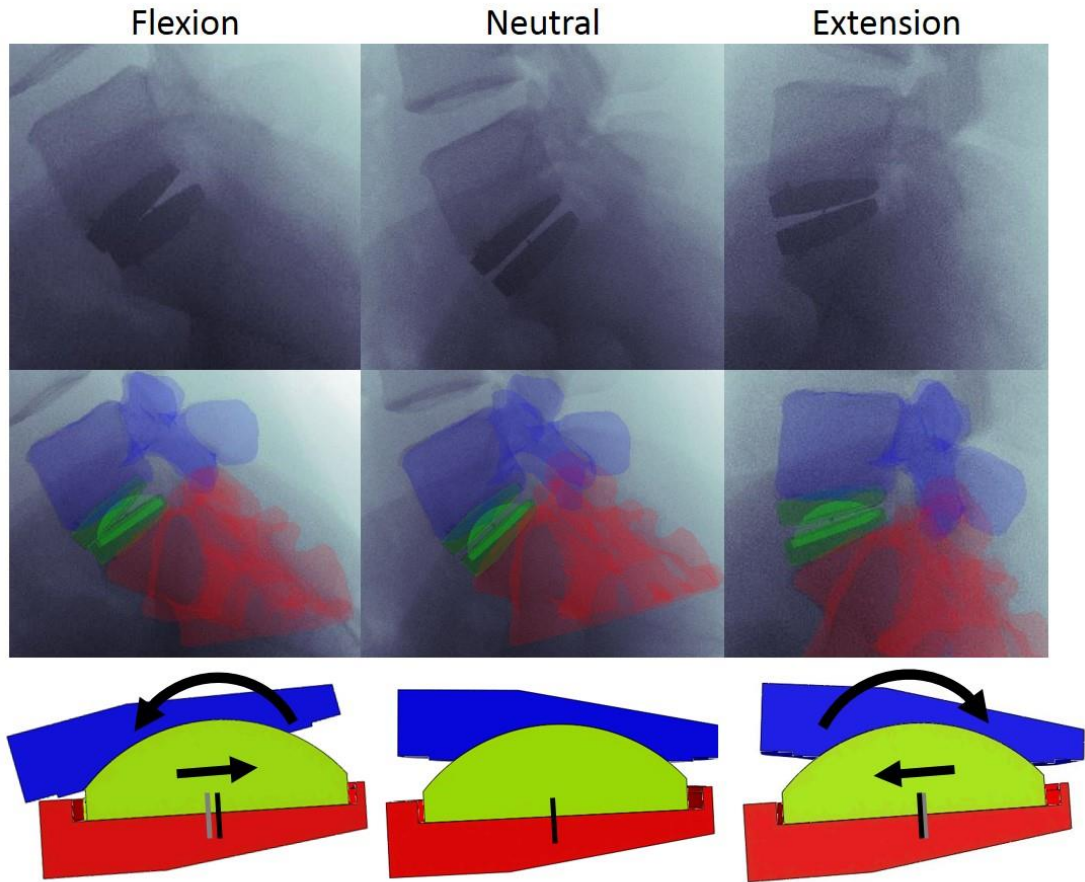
Three-dimensional model overlay with flexion-extension radiographs of Subject 2. Actual inlay translation measured from initial neutral position (gray) to final position (black). Extension and flexion ROM evaluated at actual inlay position during flexion and extension. Change in angle measured from resulting 3D model.
